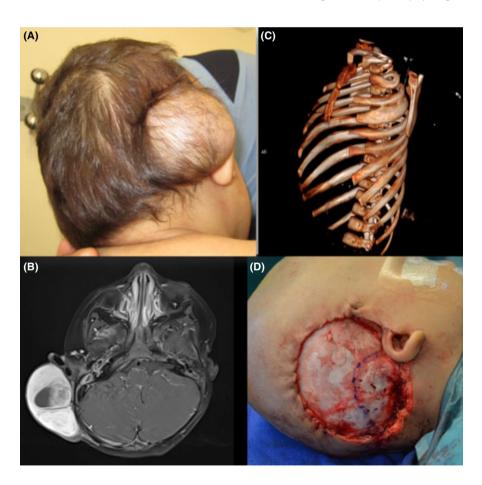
A, Clinical lateral photograph of the tumor. B, Preoperative MRI, axial view, T1 sequence after gadolinium injection. The tumor enhanced the gadolinium. C, Thoracic CT scan, 3-dimensional reconstruction showing a fusion of the 2nd and 3rd left rib. D, Preoperative view of the surgical extension
